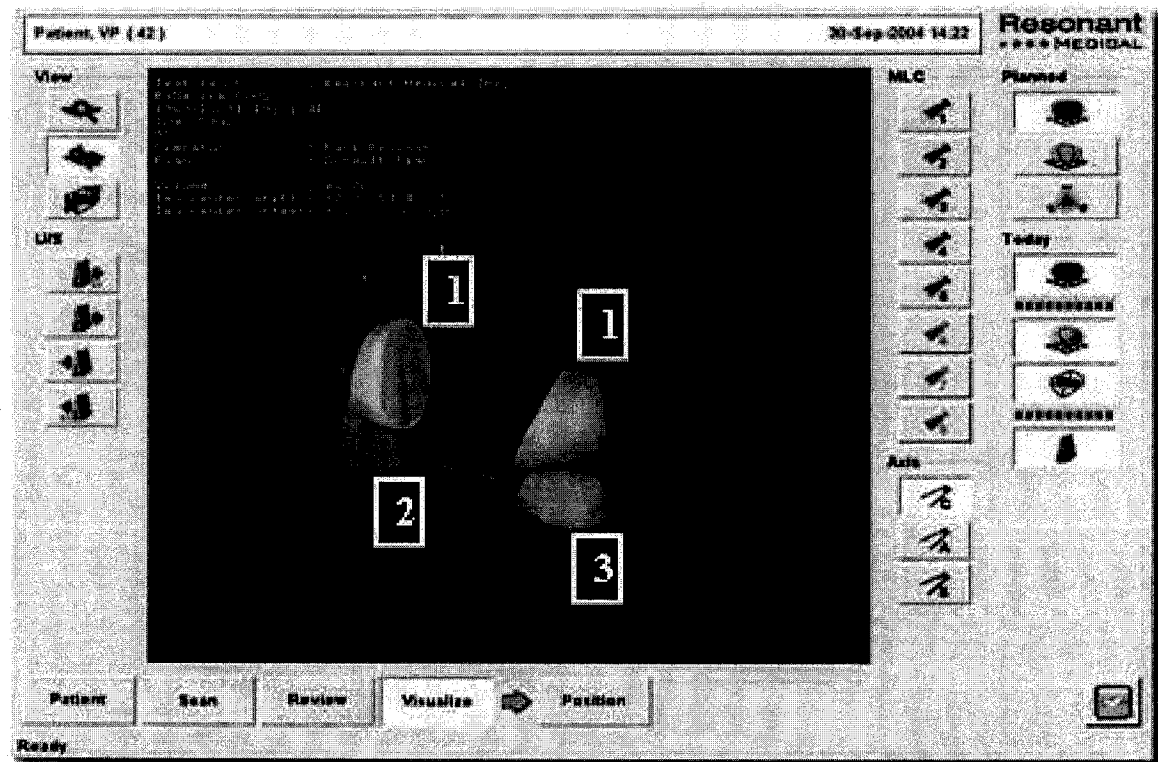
2D slice of a set of 3D US images taken with RES through a pelvic region, with the bladder (contour 1) and the prostate (contour 2) on CT day and on the first treatment day (contour 3). [Courtesy of Resonant Medical Inc].
